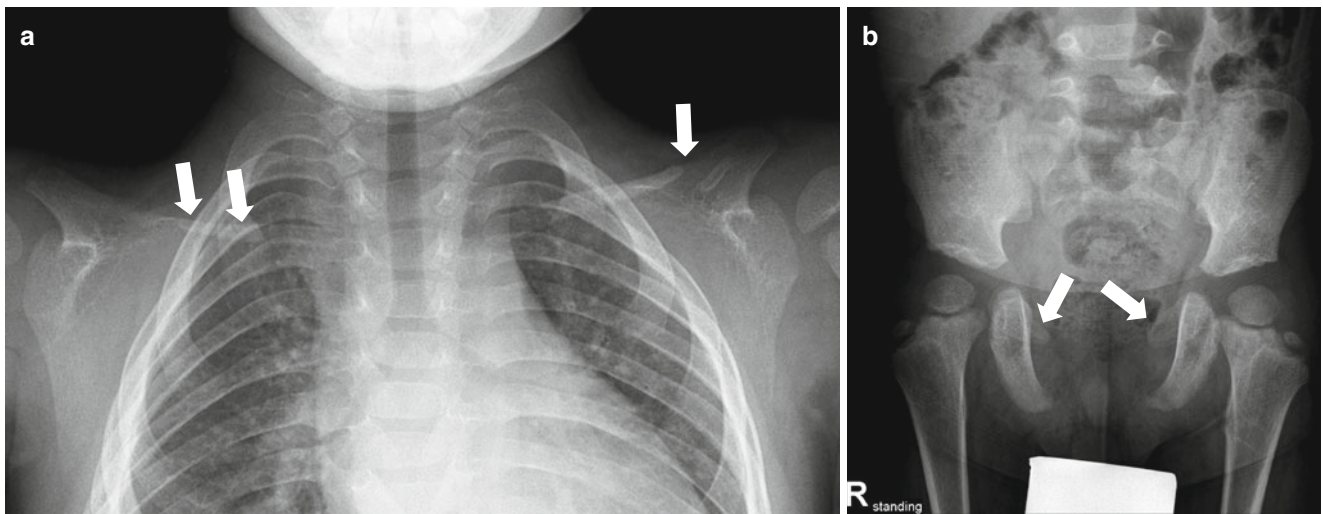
Cleidocranial dysplasia*. (a) Bilateral hypoplastic clavicles (*arrows*) are noted on chest radiograph. (b) Anteroposterior view of pelvis shows narrow iliac wing, short pubic ramus (*arrows*) with wide symphysis pubis. Coxa valga with rounded capital femoral epiphysis
